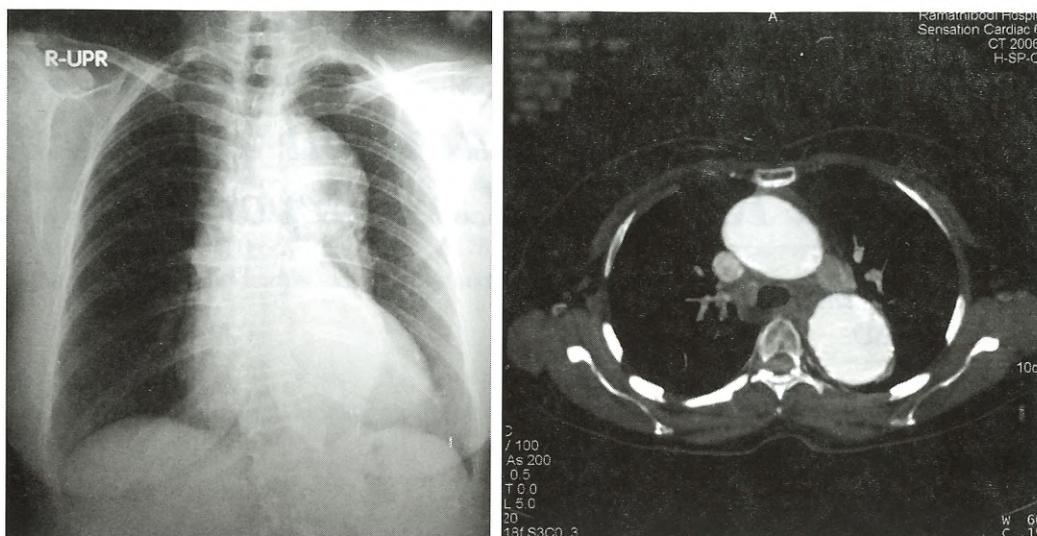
Chest x-ray and CT scan show aneurysm of both ascending and descending aorta and cardiomegaly
